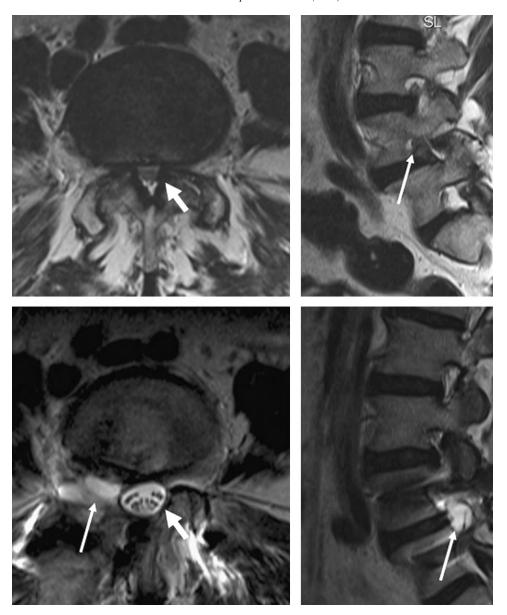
Magnetic resonance imaging images from a patient with a Grade I degenerative spondylolisthesis who underwent L4/L5 minimally invasive transforaminal lumbar interbody fusion. (Top Left, Top Right) Severe central canal stenosis (thick arrow) can be seen along with severe right L4 foraminal stenosis and nerve root compression (thin arrow). (Bottom Left, Bottom Right) Although the central canal and foramen are successfully decompressed (thick arrow), a large cyst has formed within the L4 root foramen (thin arrow). This was not causing radicular pain.
